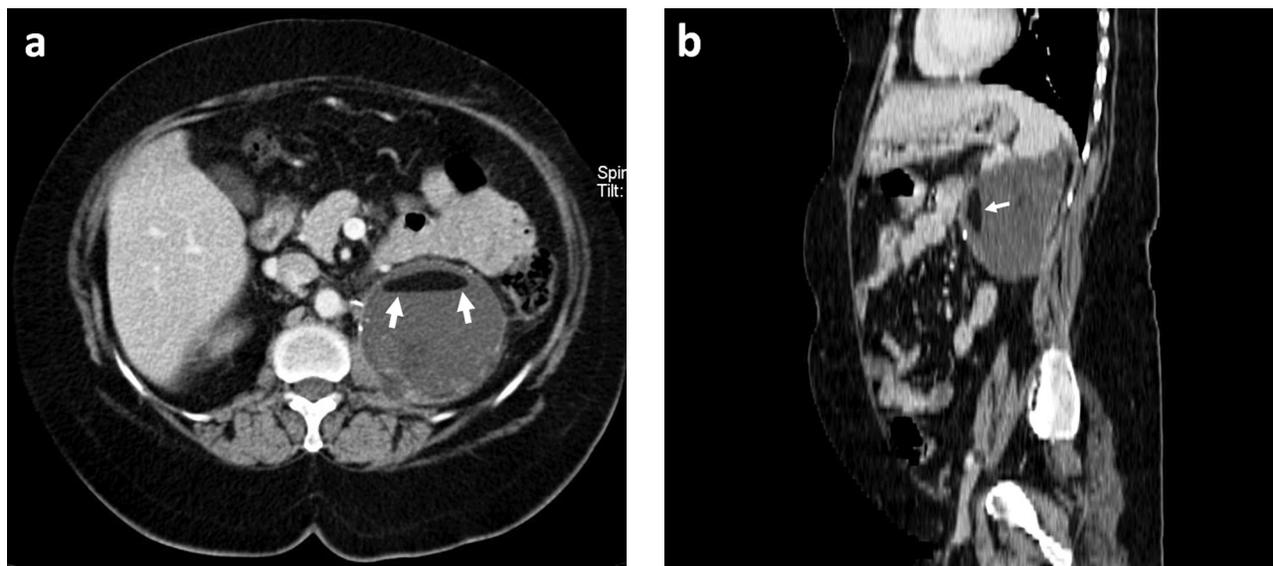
Axial (a) and sagittal (b) contrast-enhanced computed tomography images demonstrate the collection at the left adrenalectomy site with fat-fluid level anteriorly (arrows). Wall enhancement of the collection and peripheral inflammatory stranding are seen additionally (a).
